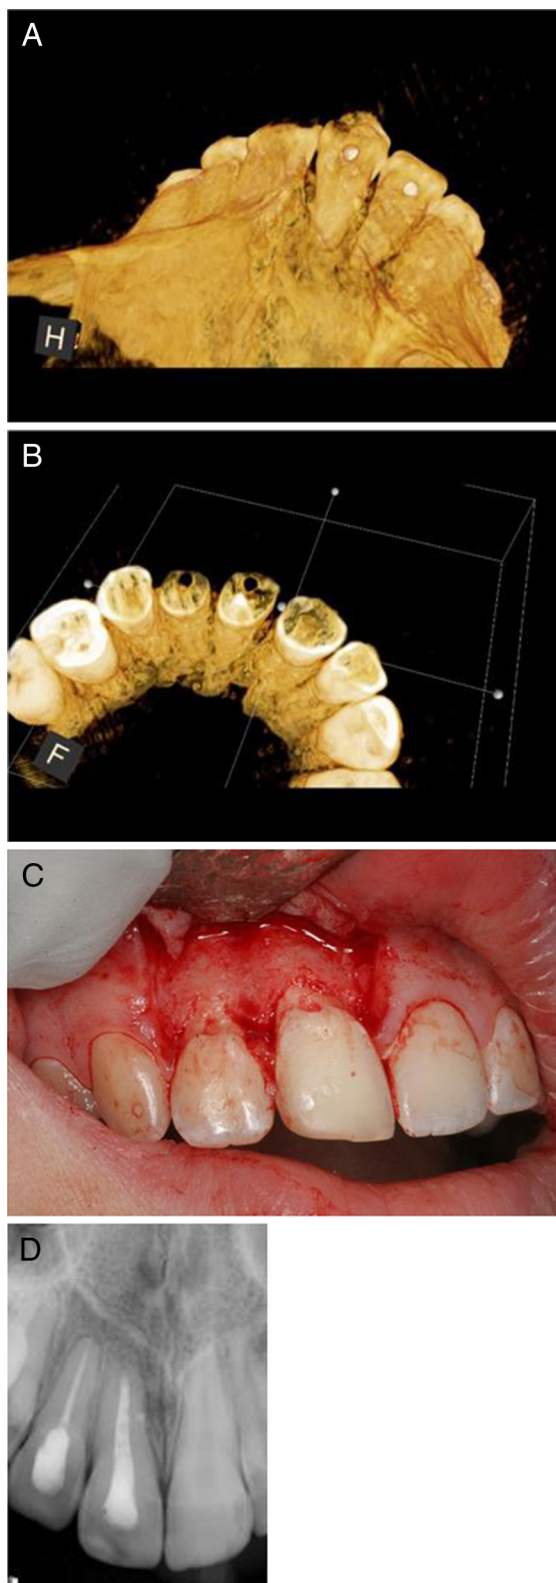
Case 1 continued: *A* and *B* are 3D reconstructions showing the buccal perforations on teeth #7 and 8. *C*) Reflection of a full-thickness mucoperiosteal flap confirmed the presence of perforations on both teeth. The perforations were repaired with Geristore (DenMat, Lompoc, CA). Both teeth were then treated via an orthograde approach with subsequent surgical root-end resection and filling of tooth #8. *D*) One-year recall radiograph showing good healing.
